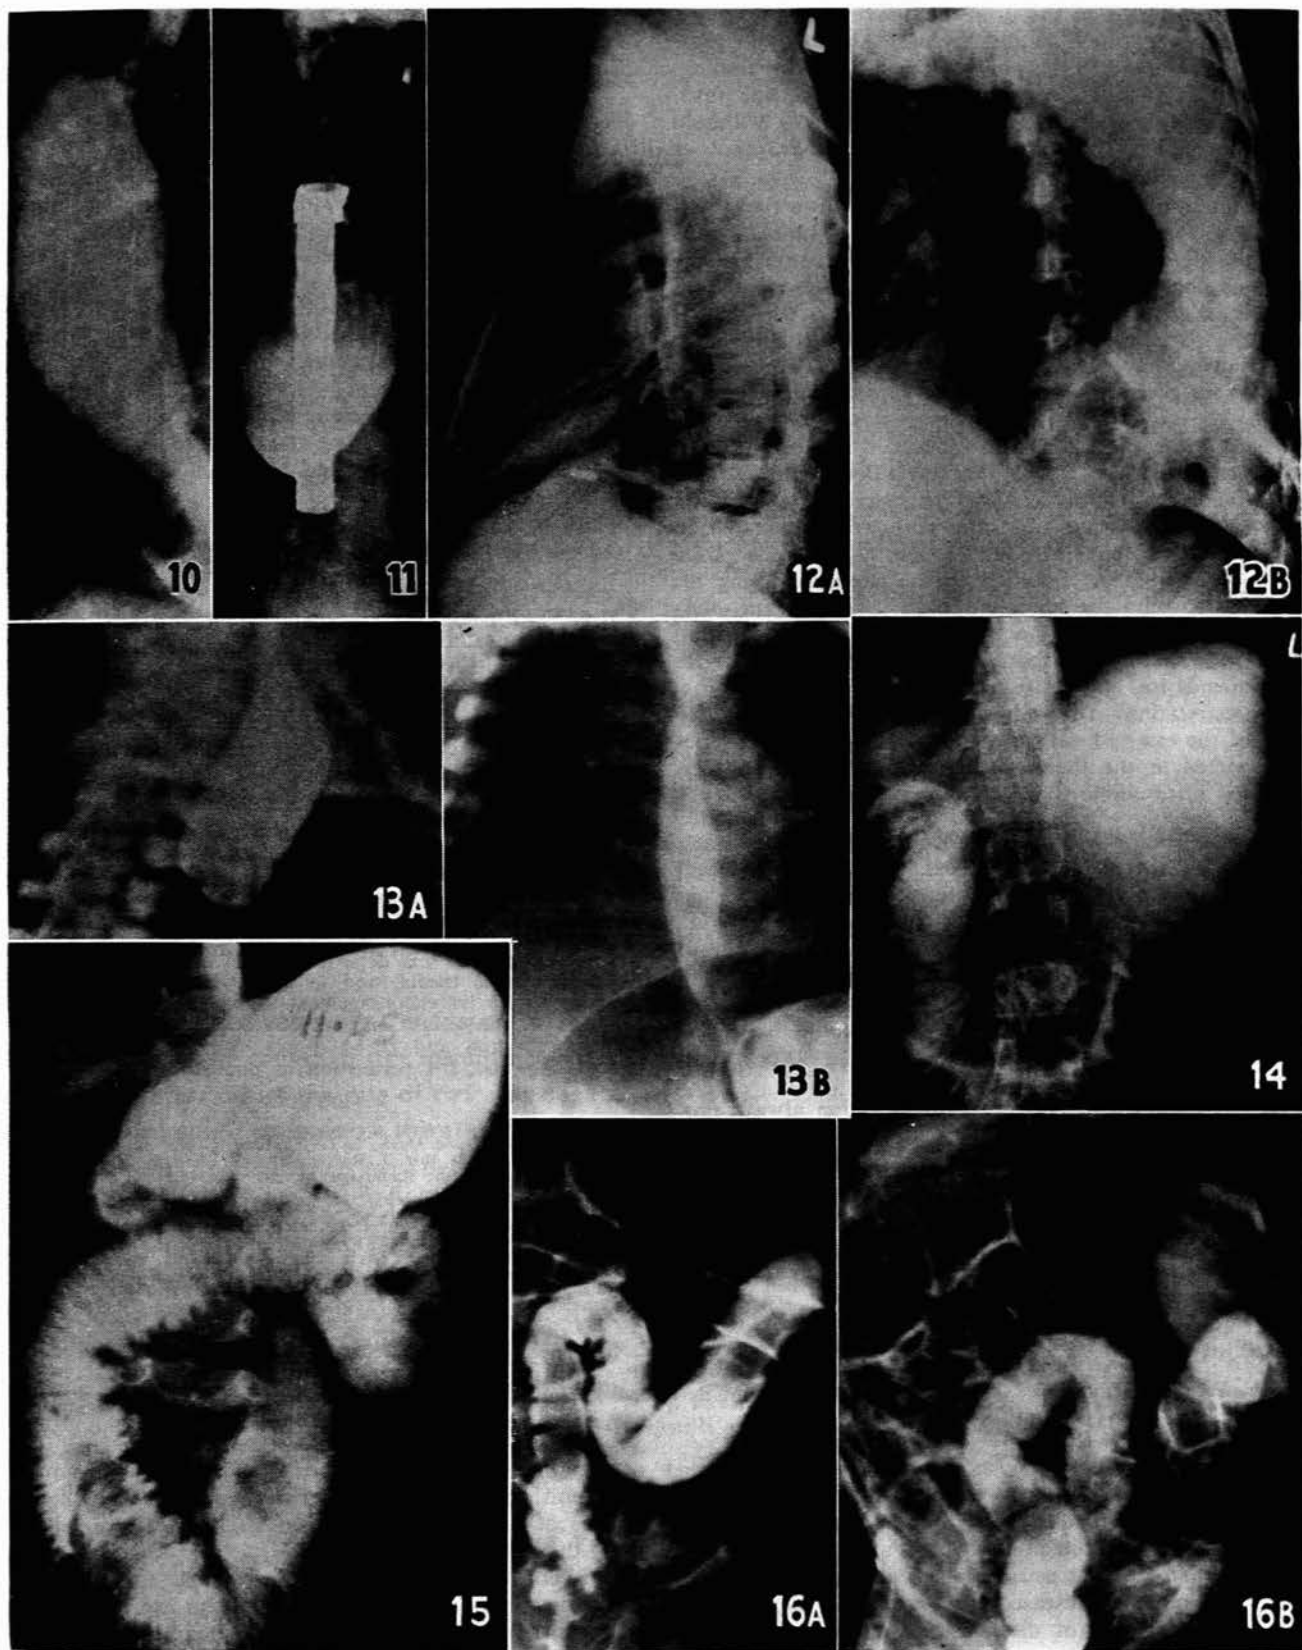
Male aged 18; stabbed left lower chest posteriorly. Empyema developing on the haemopneumothorax treated by intercostal drainage. A: Left lateral chest radiograph demonstrating left pneumothorax and suggesting a diaphragmatic hernia (as also did the postero-anterior chest radiograph). Food particles were found to emerge from the intercostal tube. B: Oblique view after oral hypaque swallow. Massive spillage of contrast medium emerges from the diaphragmatic hernia to flood the pleural space. A pyelogram was observed. No untoward effects attributable to the contrast medium were evident. At operation two stab holes were found in the gastric fundus, which was herniated through a rent in the left hemidiaphragm. Good recovery after surgical repair.
